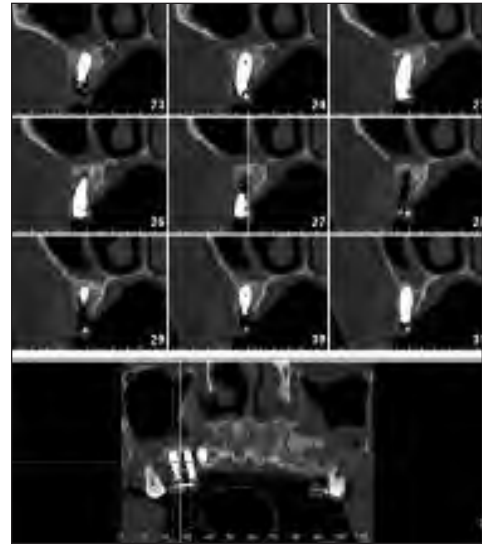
CT examination showing an adequate amount of radiopaque material and no signs of maxillary sinus disease.
